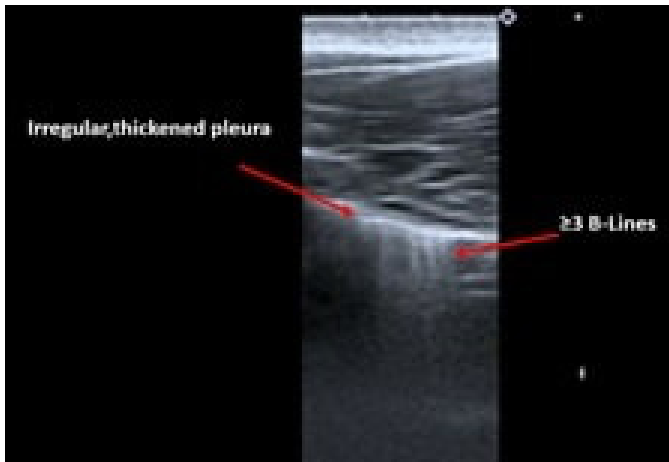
Abnormal lung ultrasound image (score 1) with irregular and thickened pleura and/or \geq 3 B-lines
